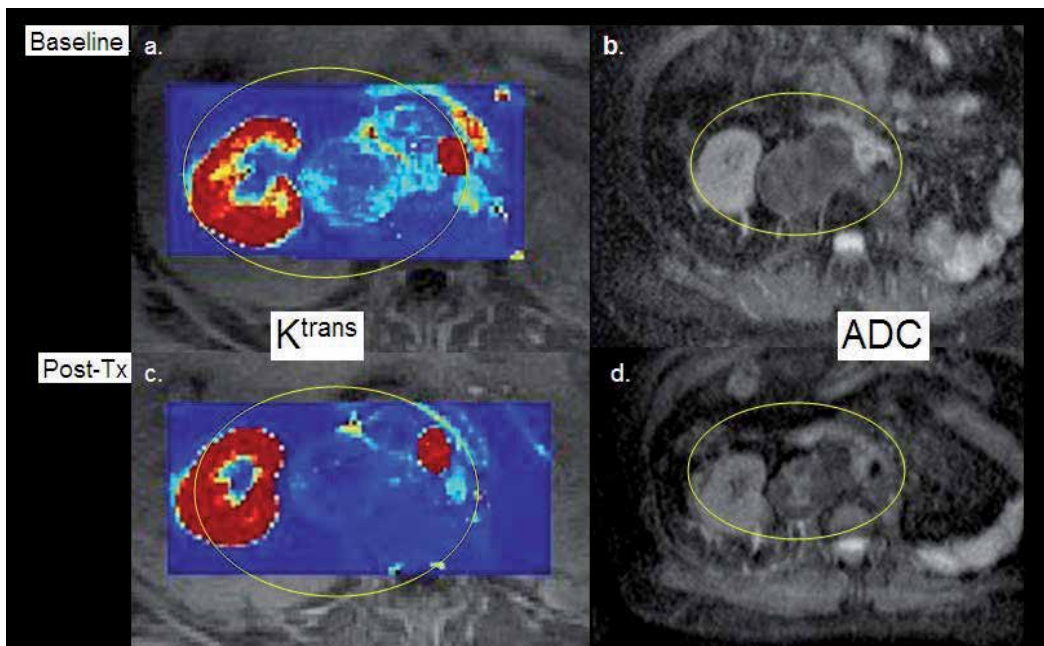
Axial MR images from a patient with known metastatic renal cell carcinoma metastatic to retroperitoneal lymph nodes. (a) Overlying T1 weighted post contrast images are parametric permeability (K^{trans}) images derived from bolus injection of gadolinium DTPA mathematically derived from analysis schemes as described in section 2.1.3. Please note the increased permeability throughout the metastatic lymph node. (b) Parametric images representing the apparent diffusion coefficient (ADC) at approximately the same level. Please note the homogeneous decreased signal intensity on ADC maps throughout the metastatic lymph node. One week following sunitinib therapy, there is dramatically decreased permeability within the metastatic lymph node on the superimposed K^{trans} map (c), and there is heterogeneously increased ADC within the metastatic lymph node (d), both of which correspond to physiologic response to therapy. Figure from Rosen et al (unpublished data).
